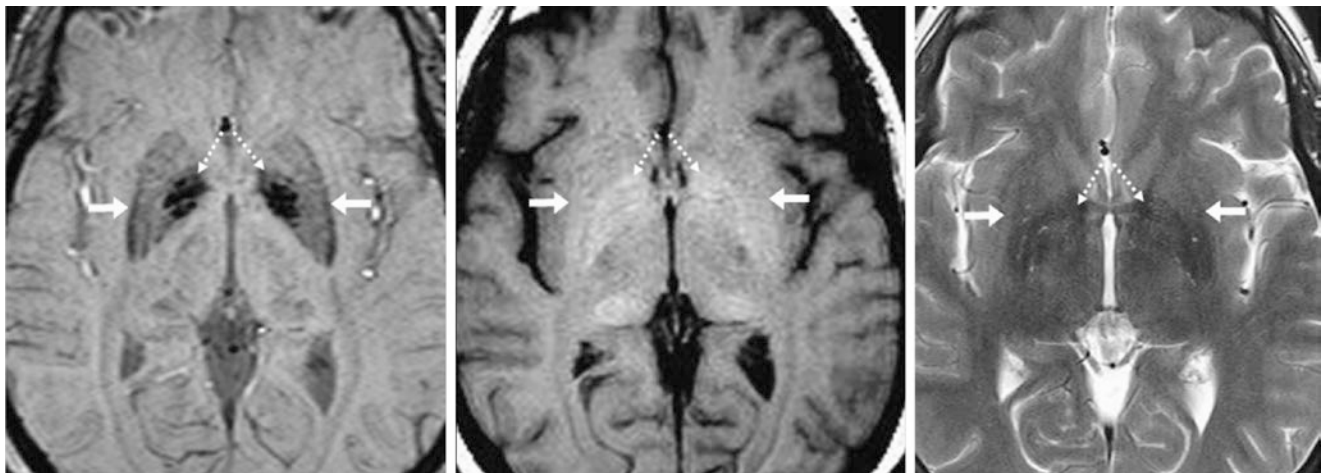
Comparison case: Manganese (Mn) deposition within the GP. A 49 year old with chronic liver disease: On a 3T MRI, the GP (*dotted arrows*) appear dark on SWI (*left*), bright on T1WI (*middle*), and dark on T2WI (*right*). On a NECT (*not shown*), no calcium was noted within the GP, thus indicating paramagnetic manganese within
